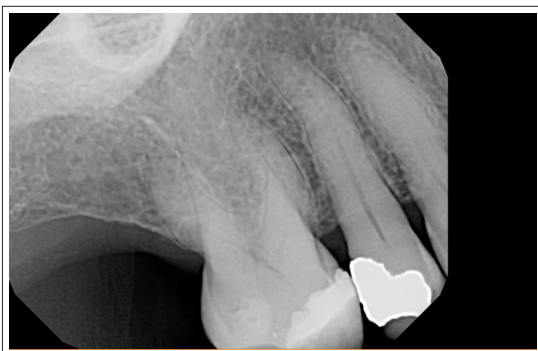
X-ray implant placement for #2
